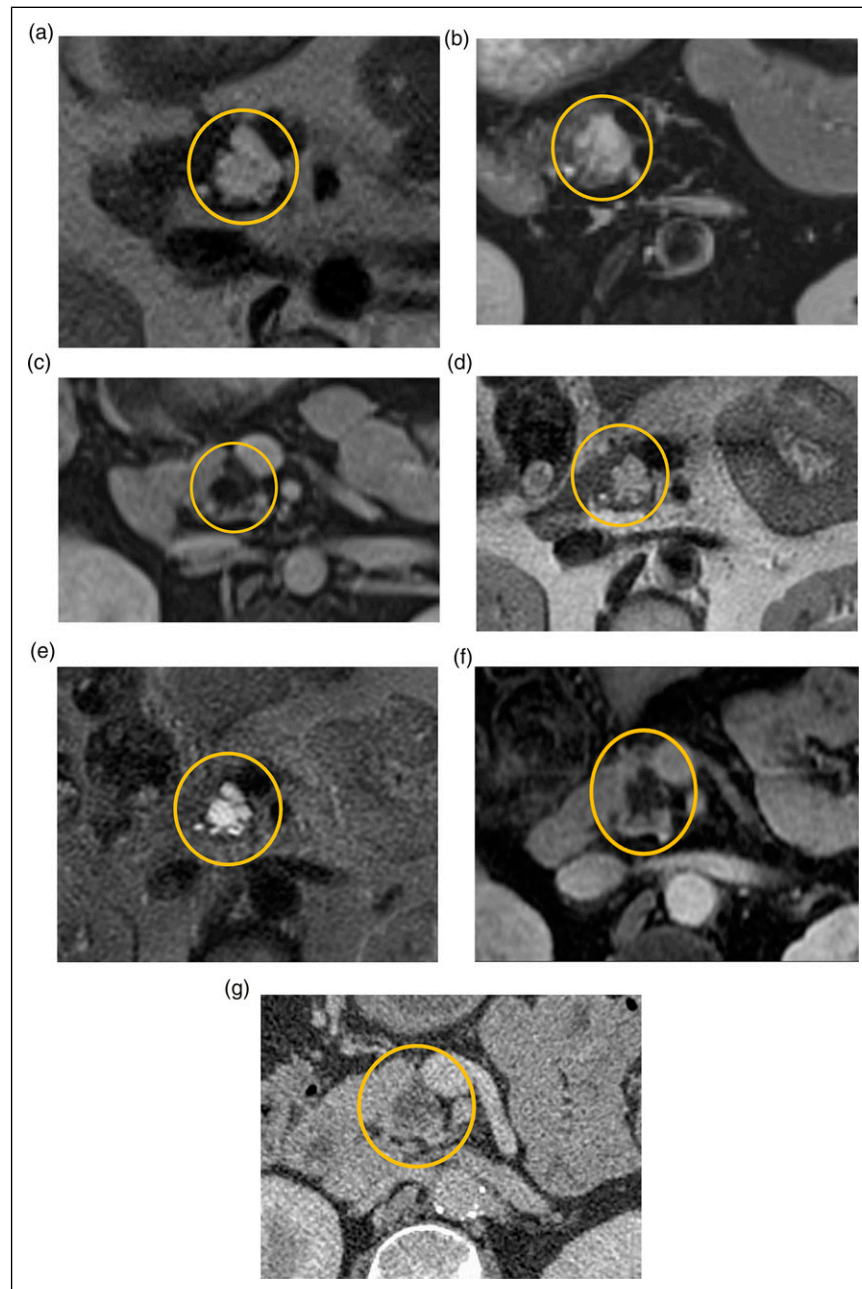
Fifty-year-old female with a 2 cm uncinus process cystic lesion (yellow circle), present since CT in 2007 and followed until 2019. (A-C) Axial T2, axial T2 fat-saturated, and axial T1 post-gadolinium images from index MRI from August of 2015. (D-F) Axial T2, axial T2 fat-saturated, and axial T1 post-gadolinium images from follow-up MRI May 2018. (G) Axial PV phase CT in 2019. The lesion demonstrated septations with minimal enhancement and no nodules or worrisome features. No intralesional calcifications on CT. The differential considerations were for a branch duct IPMN vs serous cystic neoplasm. No FNA was performed. MRI: magnetic resonance imaging; CT: Computerized tomography; IPMN: intraductal papillary mucinous neoplasms; FNA: Fine needle aspiration.
